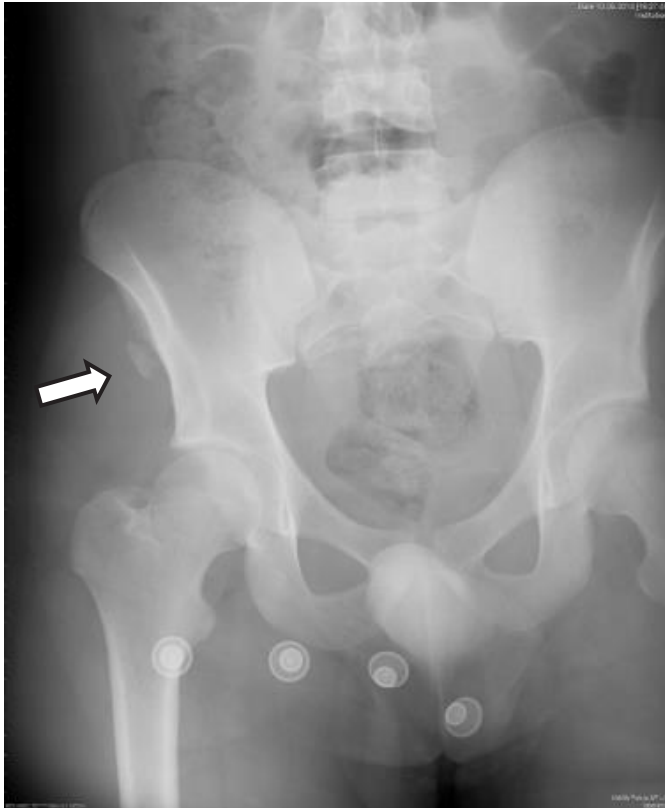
Direct X-ray appearance of the fracture
